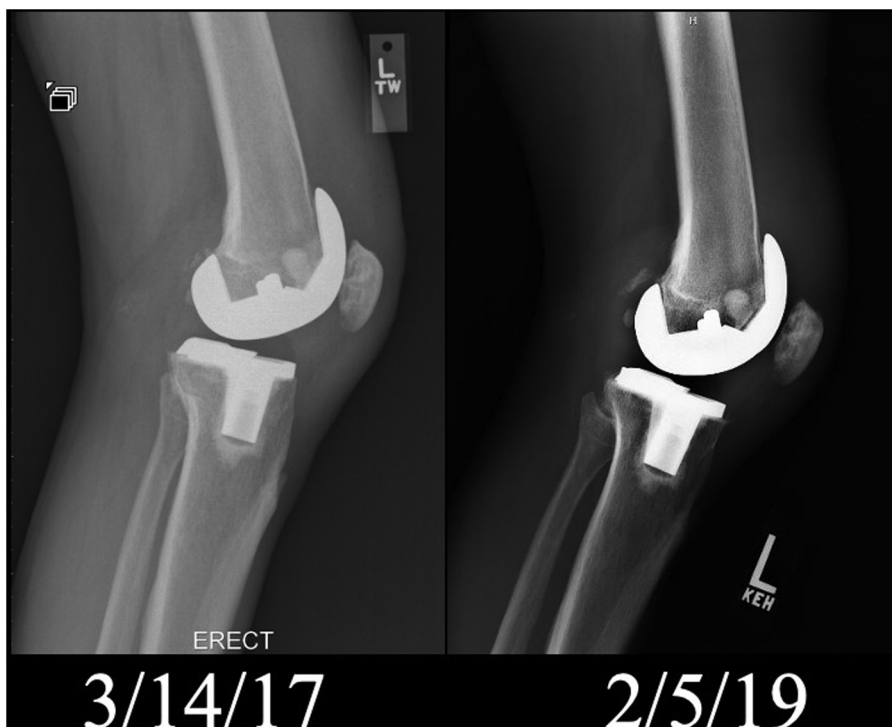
Lateral radiograph of the left knee from post op (3/14/17) and 2 year follow up (2/5/19) after primary total knee arthroplasty.
